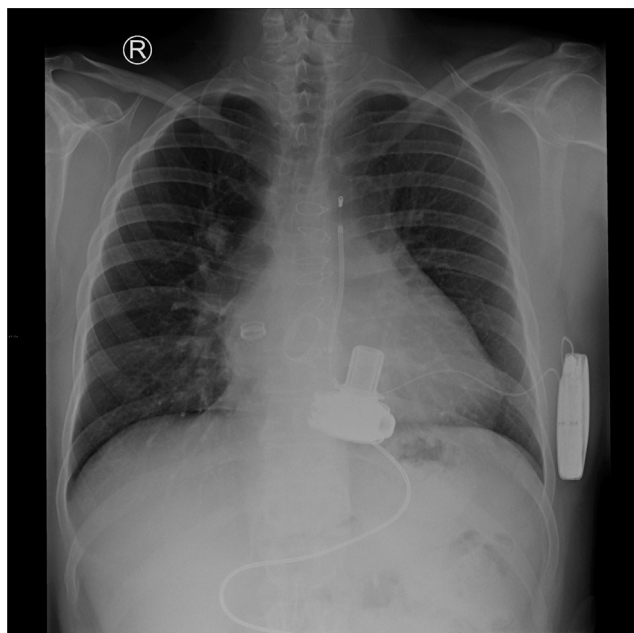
Chest radiograph of case 4 after HeartWare insertion and tissue tricuspid valve replacement. Note the previously placed subcutaneous implantable cardioverter-defibrillator.
